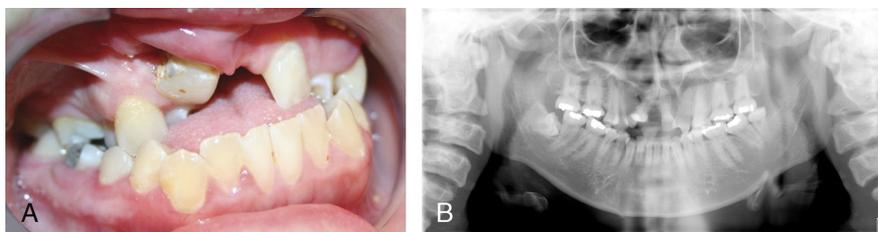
A, Intraoral photographs showing the missing maxillary lateral incisors, severe crowding, malocclusion, and anterior cross bite. B, Panoramic radiograph showing congenitally missing lateral incisors and third molars in the maxilla and an impacted right third molar in the mandible.
